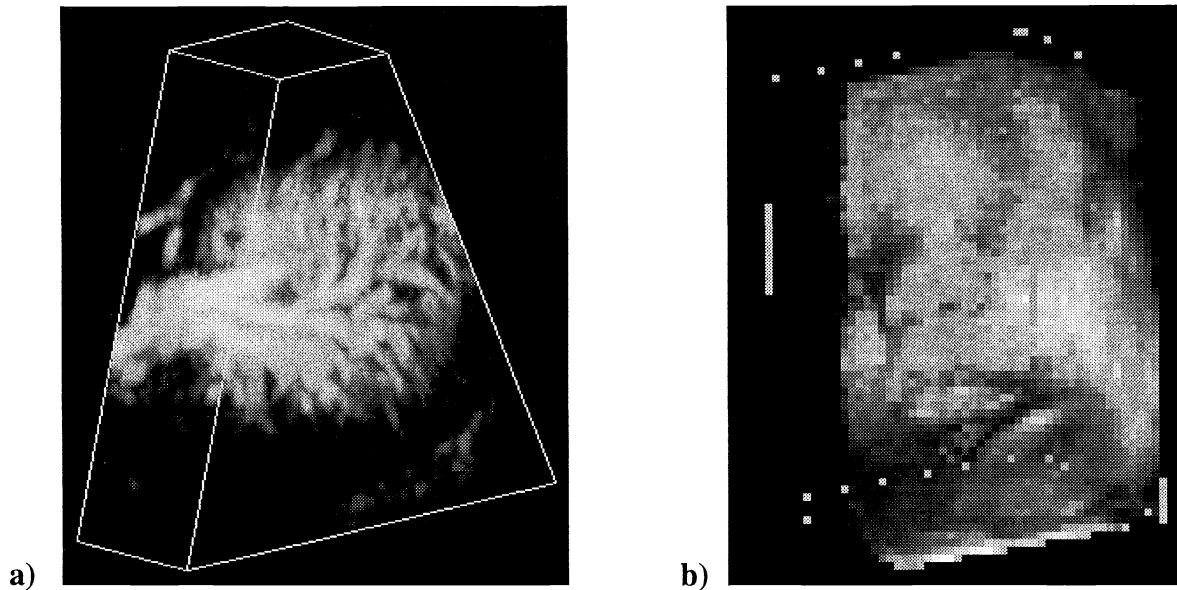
3D ultrasound images showing two volume rendering approaches of 3D US images. a) Volume rendering using maximum intensity projection of a power Doppler image of a human spleen. b) Volume rendering with enhancement of surfaces of the face of a fetus.
